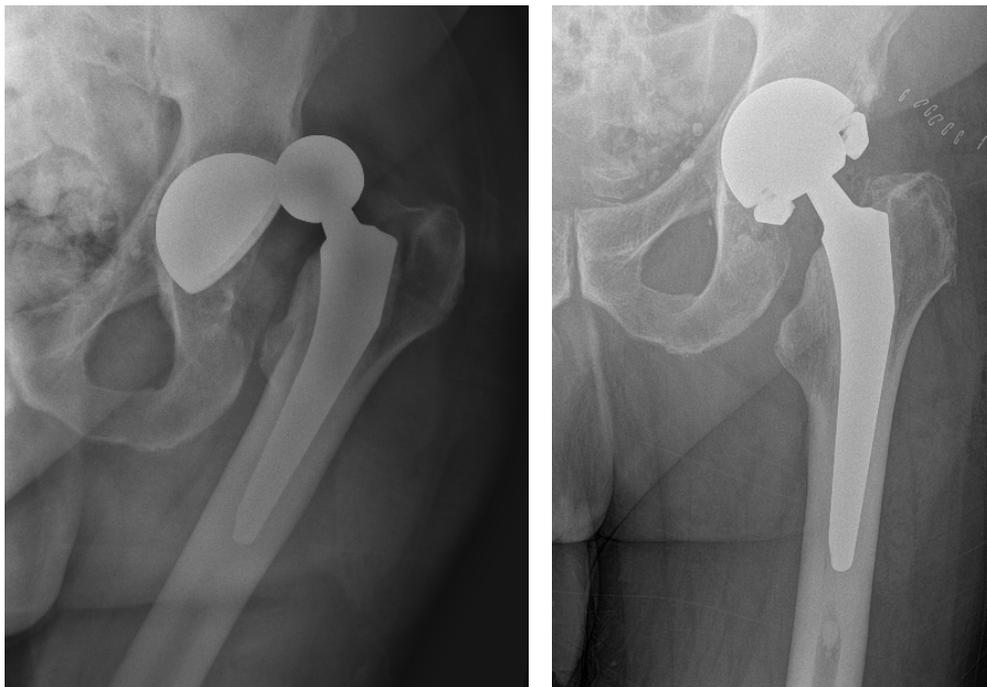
Dislocation of total hip arthroplasty and postoperative radiographs after revision to a constrained acetabular device.
